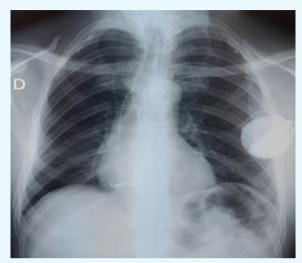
Chest X-Ray showing implanted cardioverter defibrillator
